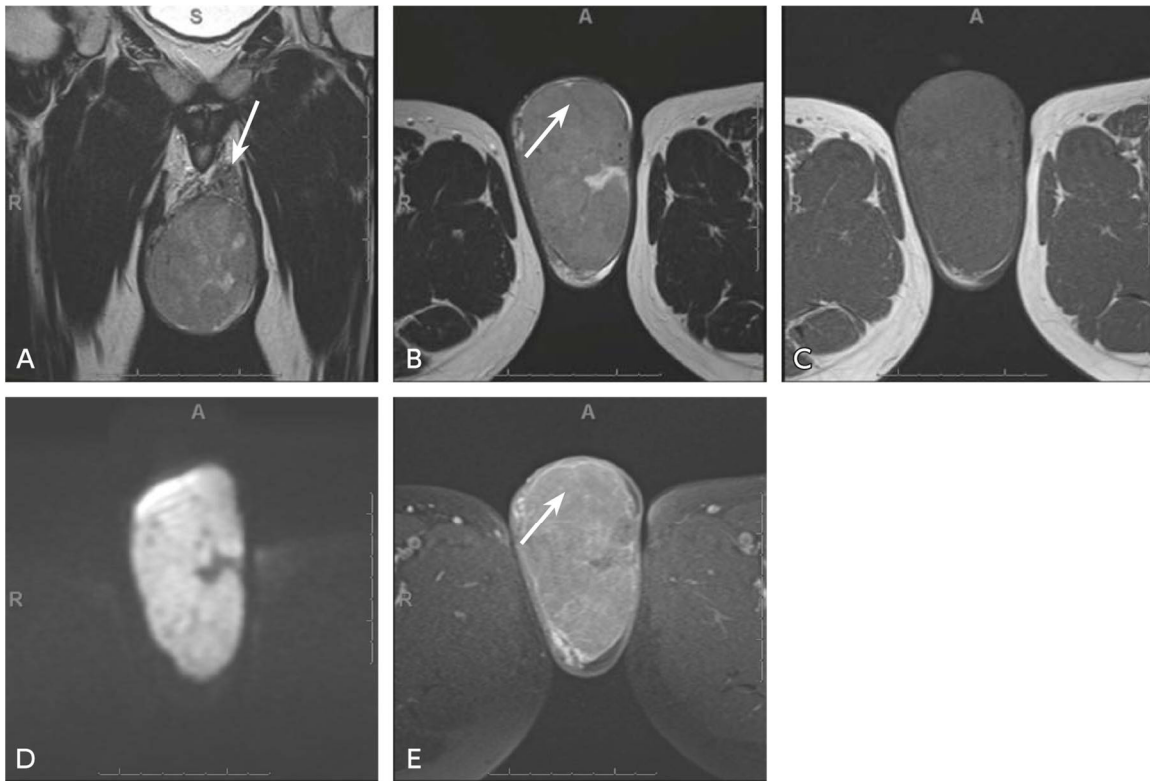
MRI of a malignant testicular tumor
